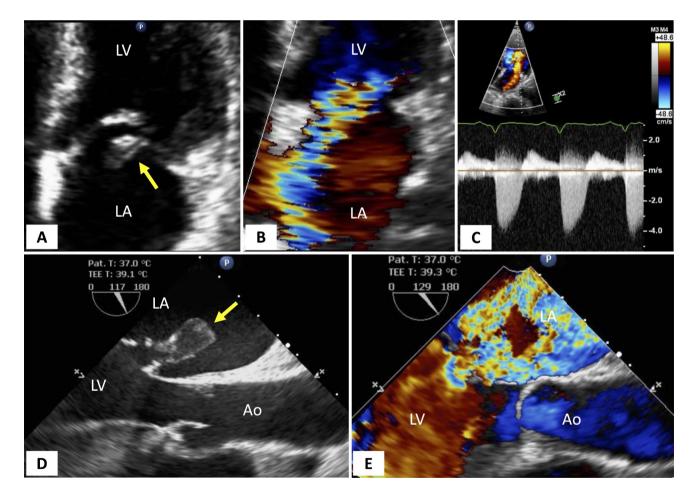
A–C Transthoracic echocardiography after a delayed presentation of an acute myocardial infarction demonstrating a flail posterior mitral valve leaflet with an associated ruptured papillary muscle (*yellow arrow*). There is severe, eccentrically directed mitral regurgitation. Continuous-wave Doppler demonstrates a densely echogenic profile, with a low peak velocity (<5 m/s) and an early peaking, asymmetric, triangular shape. D, E Transesophageal echocardiography demonstrating flail segments of the anterior and posterior mitral valve leaflets with associated chordae tendinae and a ruptured papillary muscle (*yellow arrow*). There is severe, eccentrically directed mitral regurgitation. *Ao*, aorta; *LA*, left atrium; *LV*, left ventricle
